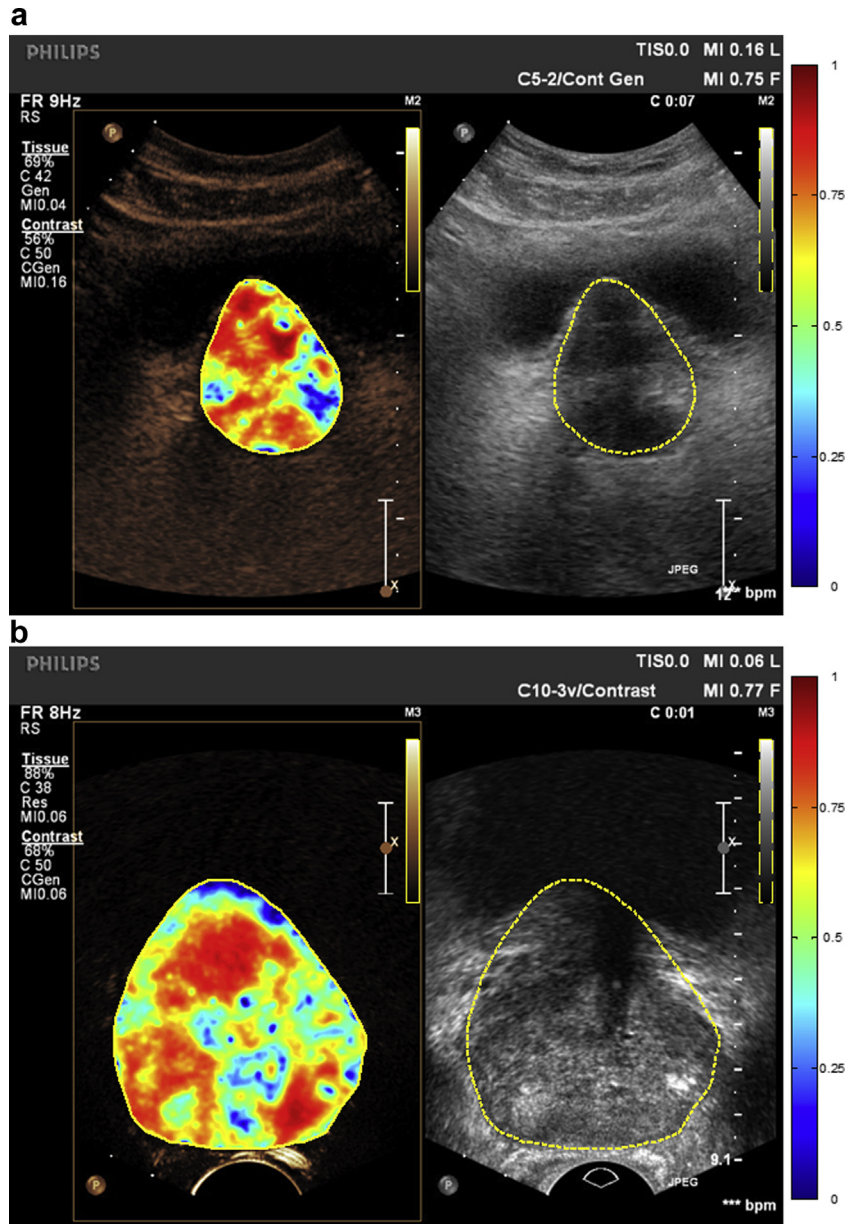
Functional images of dispersion estimated by the method described in Mischi et al. (2012) for the transabdominal (a) and transrectal (b) ultrasound scans in the same patient presented in Figures 1 and 2. Both maps reveal the prostate extension into the bladder as angiogenic (red color).
